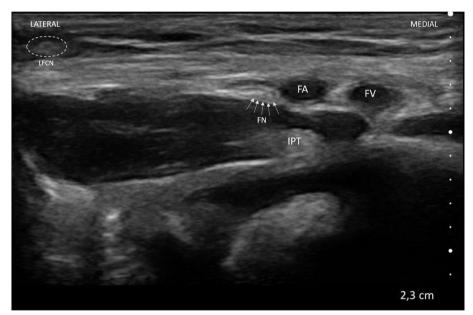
Ultrasound image of a 4-month-old male infant 8.5 kg in weight and 68 cm in length. The lateral femoral cutaneous nerve (LFCN) is included in the image and is located on the needle trace. White arrows point to the femoral nerve. Dashed line encircles LFCN. FA: femoral artery, FN: femoral nerve, FV: femoral vein, IPT: iliopsoas tendon, LFCN: lateral femoral cutaneous nerve
